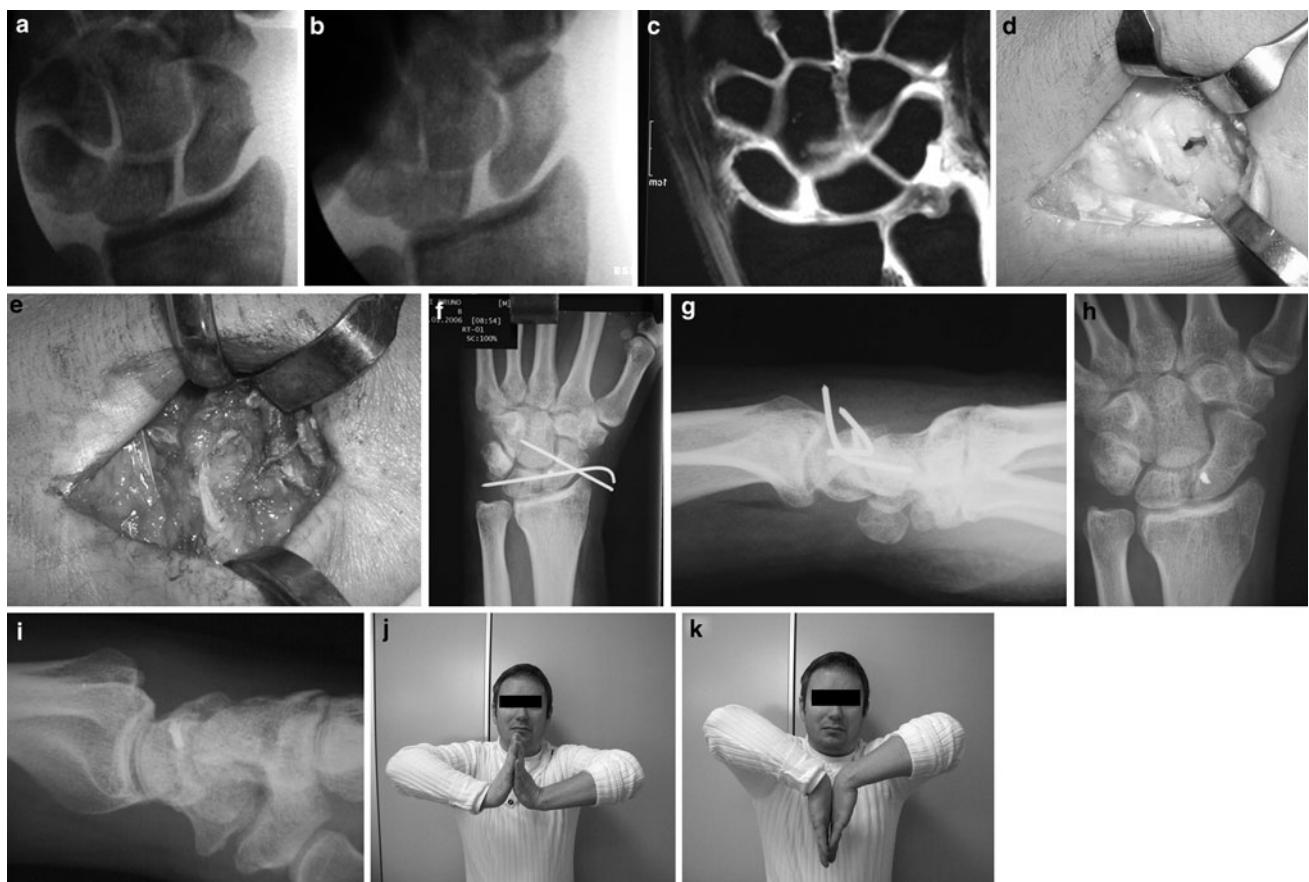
A 31-year-old man sustained a closed wrist injury due to a sport accident. a, b The fluoroscopic evaluation of the wrist showed the presence of a dynamic scapho-lunate instability under stress maneuvers (CIND). c The diagnosis was confirmed with an arthro-MRI that shows the contrast leakage in the midcarpal joint. d, e An open reduction of scaphoid and lunate was performed through a dorsal access. The torn scapholunate ligament was reinserted on the scaphoid through a minianchor MITEK®. f, g Post-surgical
